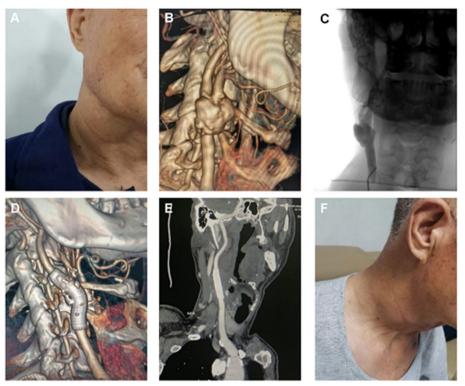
Typical case 2; A 71-year-old male with hyperlipidemia and a smoking habit of 1 pack per day presented with a pulastile neck mass that had been present for 4 months. The mass was observed on the right side of the neck (A), and the patient was found to be neurologically intact upon examination. Further investigation through a CTA examination revealed an unruptured aneurysm in the right ECCA (B). Cerebral angiogram revealed a giant aneurysm (21.0 mm in maximum diameter) on the extracranial internal carotid artery (C), and was reconstructed with a 4.0-16 mm Willis (D). One month after the operation, the patient took oral anti-infective drugs. Upon re-examination angiography, it was found that the aneurysm had completely disappeared and the blood flow through the parent artery was smooth (E). Additionally, the pulsating mass in the neck had also disappeared (F)
